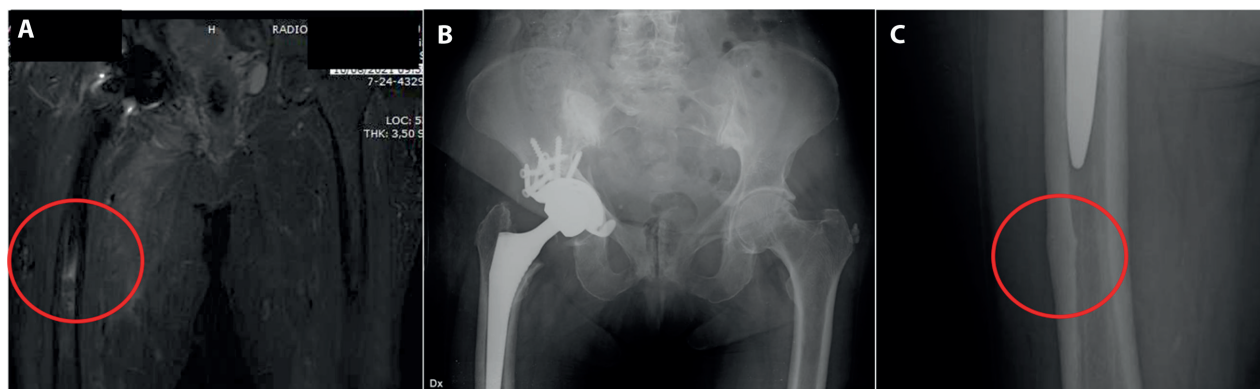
(A) Post operative MRI shows edema only in the right atypical femoral fracture. (B) 6 months x ray shows no signs of implant mobilization (C) after anabolic therapy the thin lateral radiolucency is disappeared.
